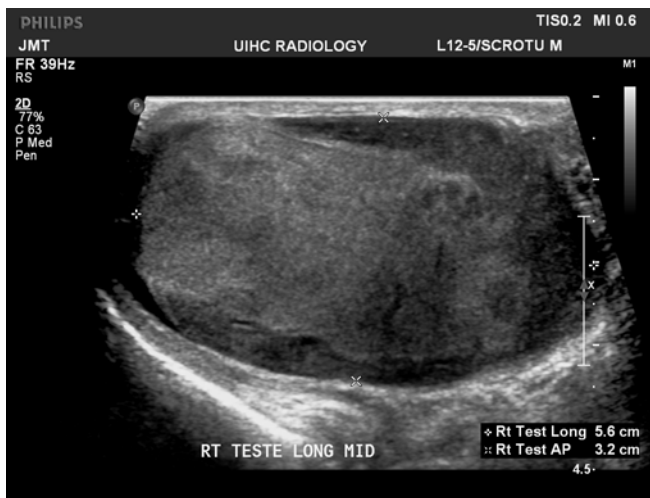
Repeat ultrasound exam with color Doppler done 3.5 months later continues to show multiple hypochoic areas. The right testis also appears larger, more heterogeneous and rounded in shape suggestive of an enlarging mass.
